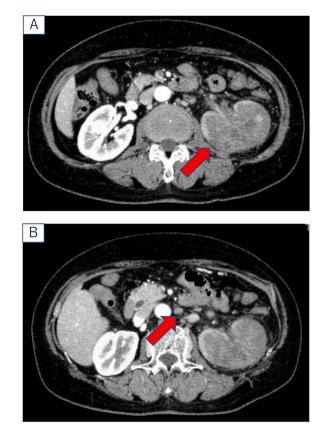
The abdominal contrast-enhanced computed tomography (CECT) findings. (A) The CECT showed 9.0×7.0 cm hypovascular tumors near the lower pole of the left kidney. (B) The CECT showed enlarged para-aortic lymph nodes.
